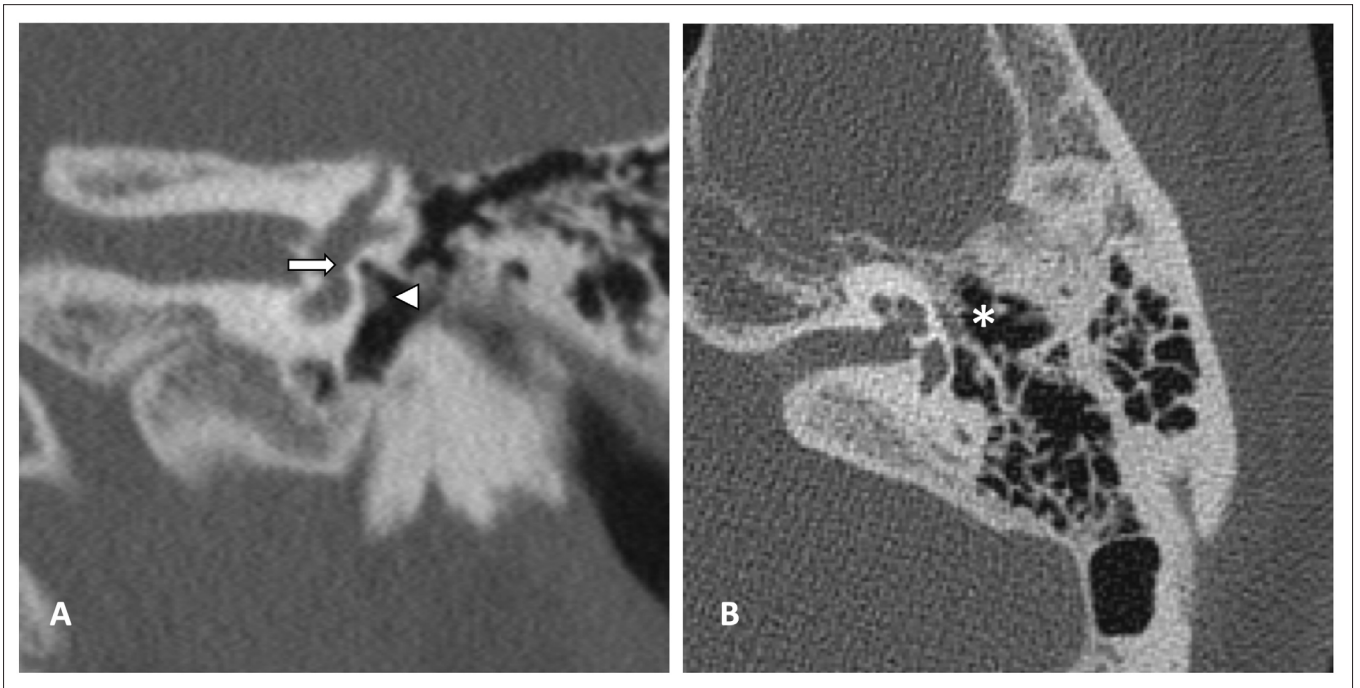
HRCT of Patient G1 with left oval window atresia, inferiorly displaced facial nerve and absent stapes. (A) Coronal section of the left ear: absence of the normal oval window at its expected location (arrow). The facial nerve is displaced inferiorly, located at the level of the cochlear promontory (arrowhead). (B) Axial section of the left ear: the stapes is absent (asterisk).
